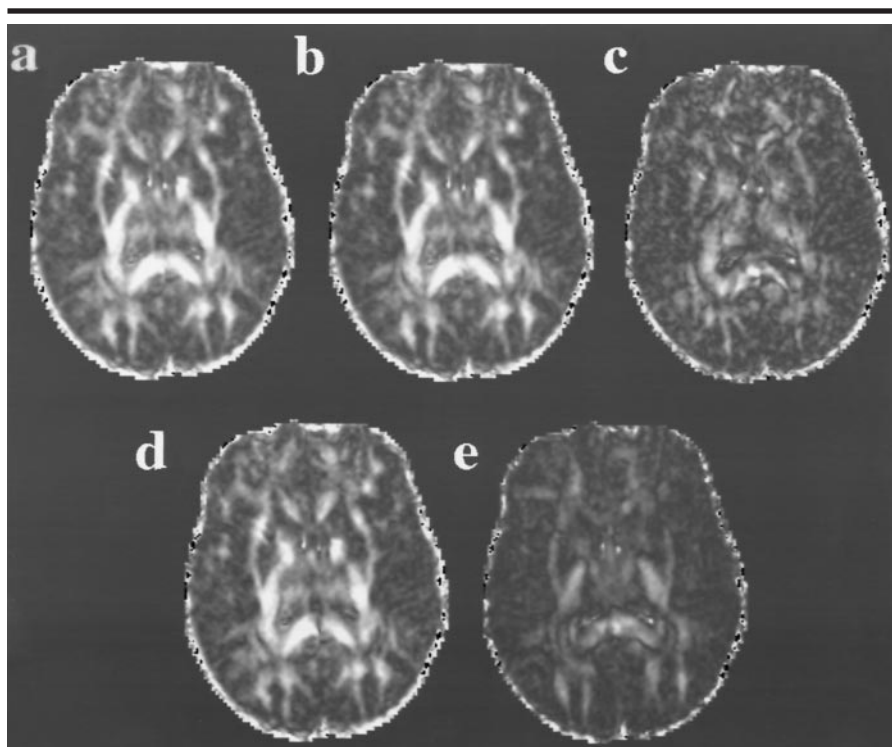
Axial anisotropy (*a–c*) and anisotropy-weighted (*d, e*) MR images computed at the level of the basal ganglia by using the data in Figure 1. A_r (*a*), A_{major} (*b*), and A_{minor} (*c*) images were obtained from a single acquisition of combined tetrahedral-orthogonal encoding. *d*, AW_{tet} image was obtained from the tetrahedral encodings. *e*, AW_{ortho} image was obtained from the orthogonal encodings. All images have the same window width and center. Note the high sensitivity to WM depiction in *a*, with delineation of the external capsule, the peripheral occipital WM projections, the thalamic heterogeneity, and the width of the internal capsule. Note also the structural heterogeneity of WM in *a* (eg, dark bands between the internal capsule, corpus callosum, and adjacent WM) and the heterogeneity in the thalamus, which is not seen on T2-weighted MR images (see Fig 1, *h*). Visible differences in anisotropy strength exist between WM classes, where the image intensity in *a* and *b* can be ranked, from highest to lowest, as follows: commissural WM, projection WM, and association WM. In comparison with *a*, the anisotropy-weighted component images in *d* and *e* show a loss of intensity in the splenium and genu of the corpus callosum, respectively, and there generally is less intensity in *e*, as compared with that in *d*.
